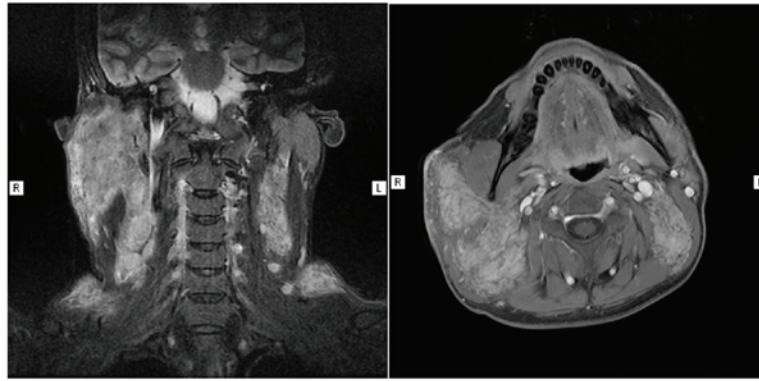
Magnetic resonance imaging examination showing widespread abnormal signal was detected. Administration of contrast material revealed uneven enhancement.
